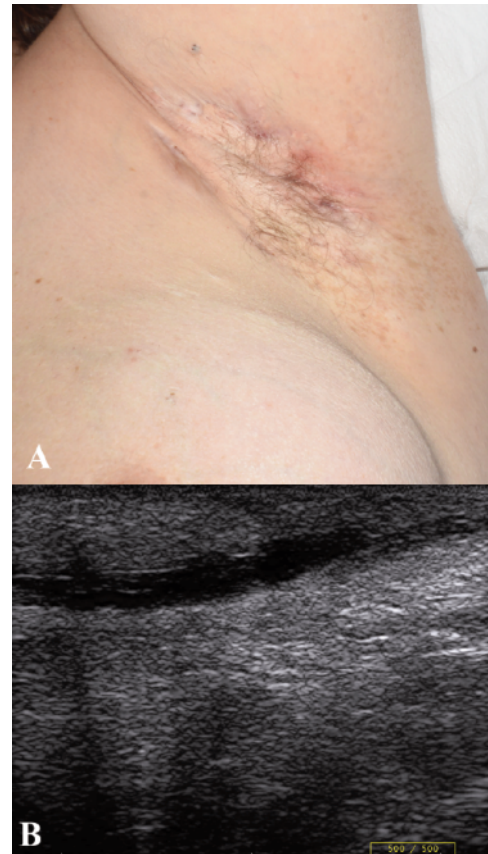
A) Clinical picture of the right armpit after 52 weeks of treatment; B) ultrasound picture of the draining tunnel in the right armpit after 52 weeks of treatment (fibrosis score 1, edema score 0).
